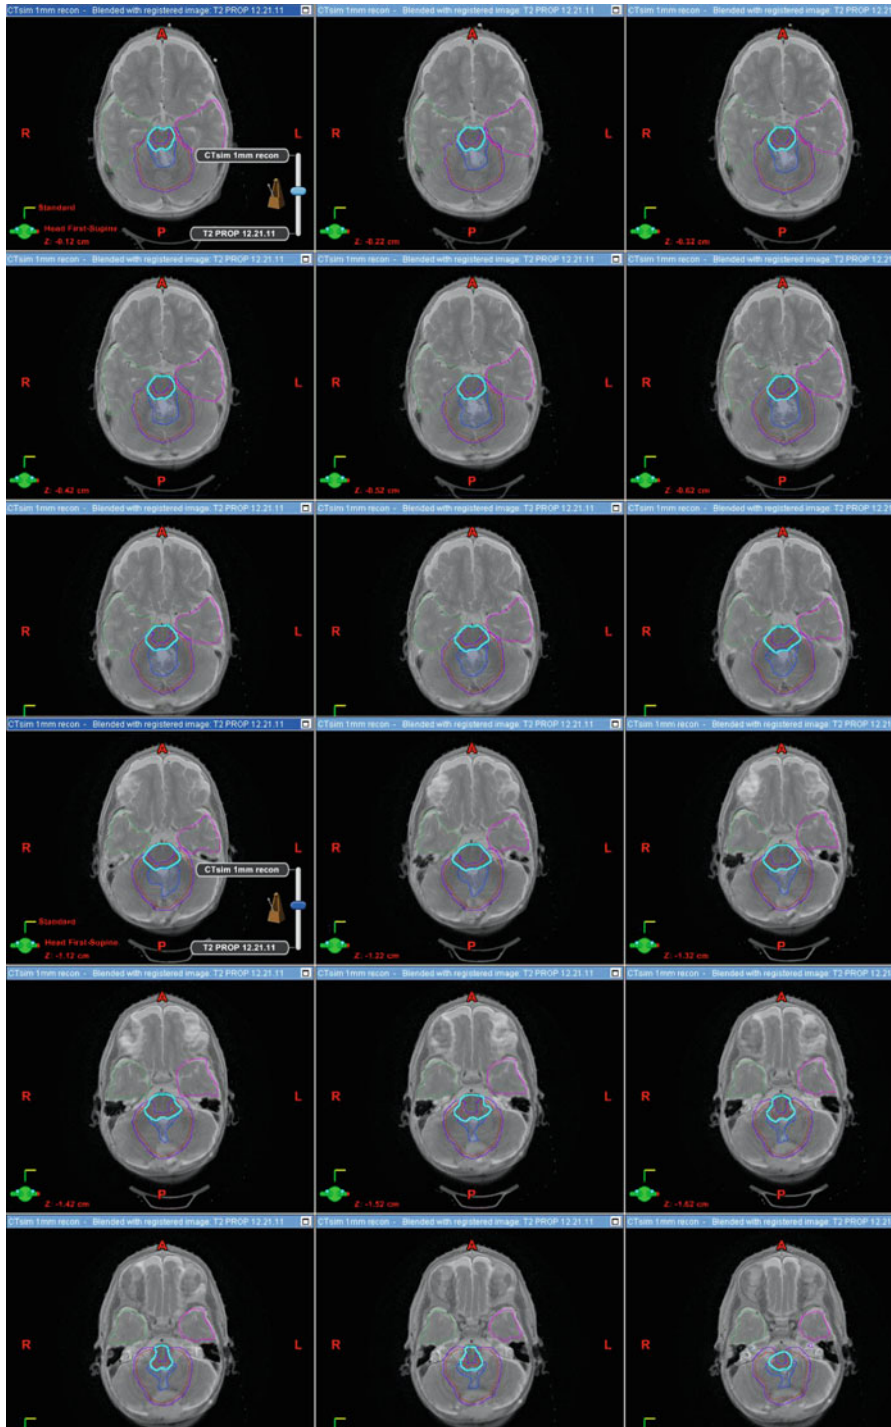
MRI slices from the above patient’s plan fused to the above CT scan. Brain stem is outlined in aqua
